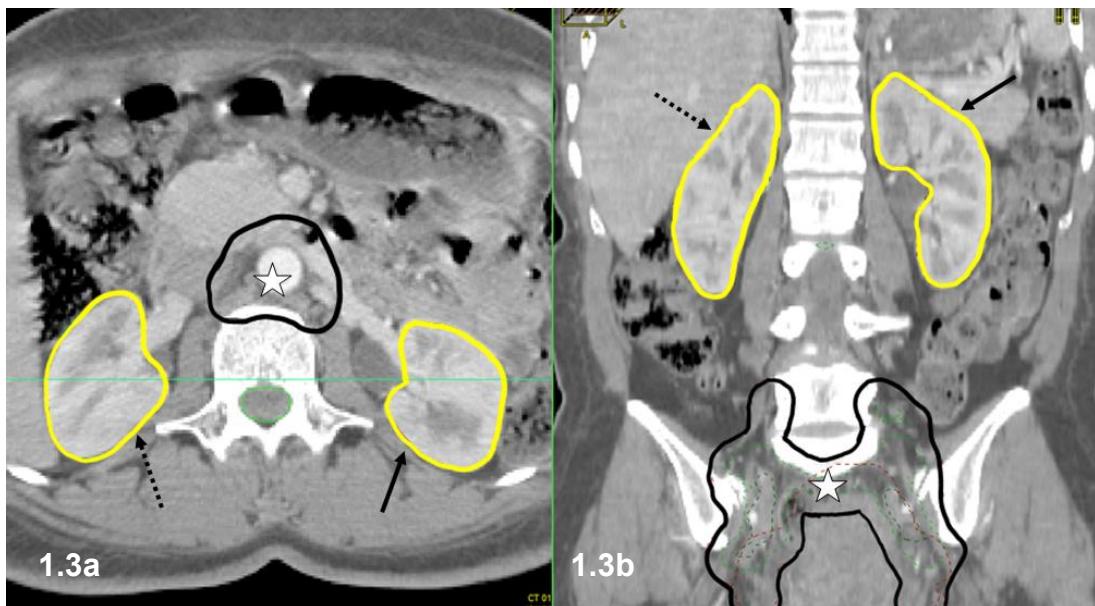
Axial (a) and coronal (b) CT of patient receiving para-aortic nodal radiotherapy (PTV starred) with left (solid arrow) and right (dashed arrow) kidneys outlined.
